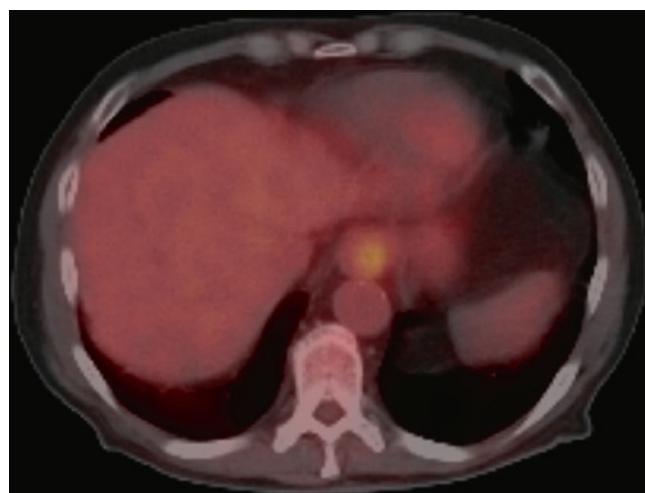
PET scan reveals focal soft tissue thickening with increased uptake of FDG in the distal esophagus at the gastroesophageal junction consistent with esophageal carcinoma.
